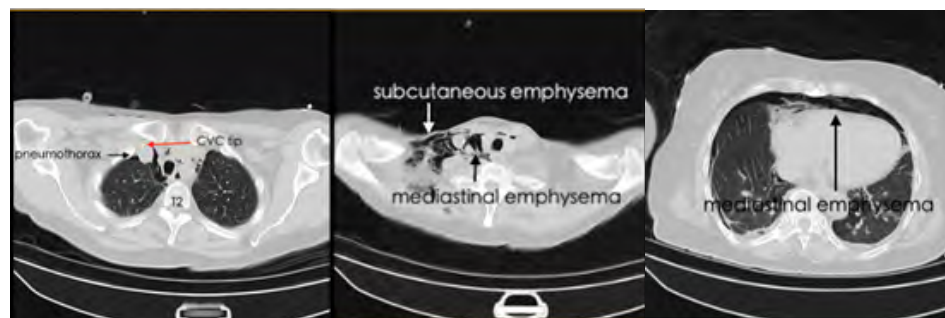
Chest CT (the day of the surgery) : Right-sided pneumothorax, subcutaneous emphysema, mediastinal emphysema, and the tip of the CVC was partially extravascular.
